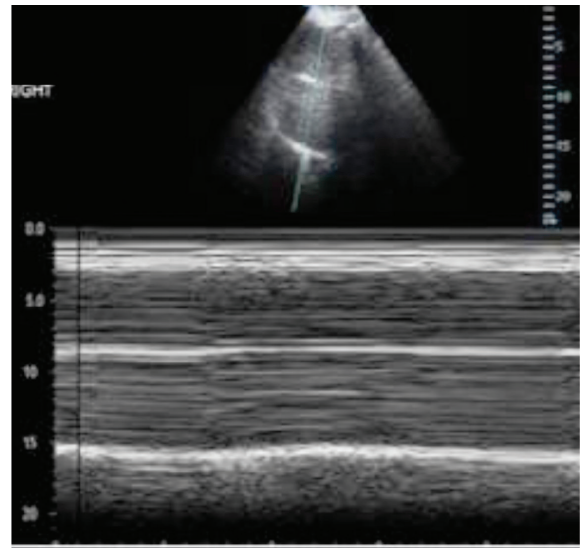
Diaphragmatic paralysis was detected in the thorax ultrasound
